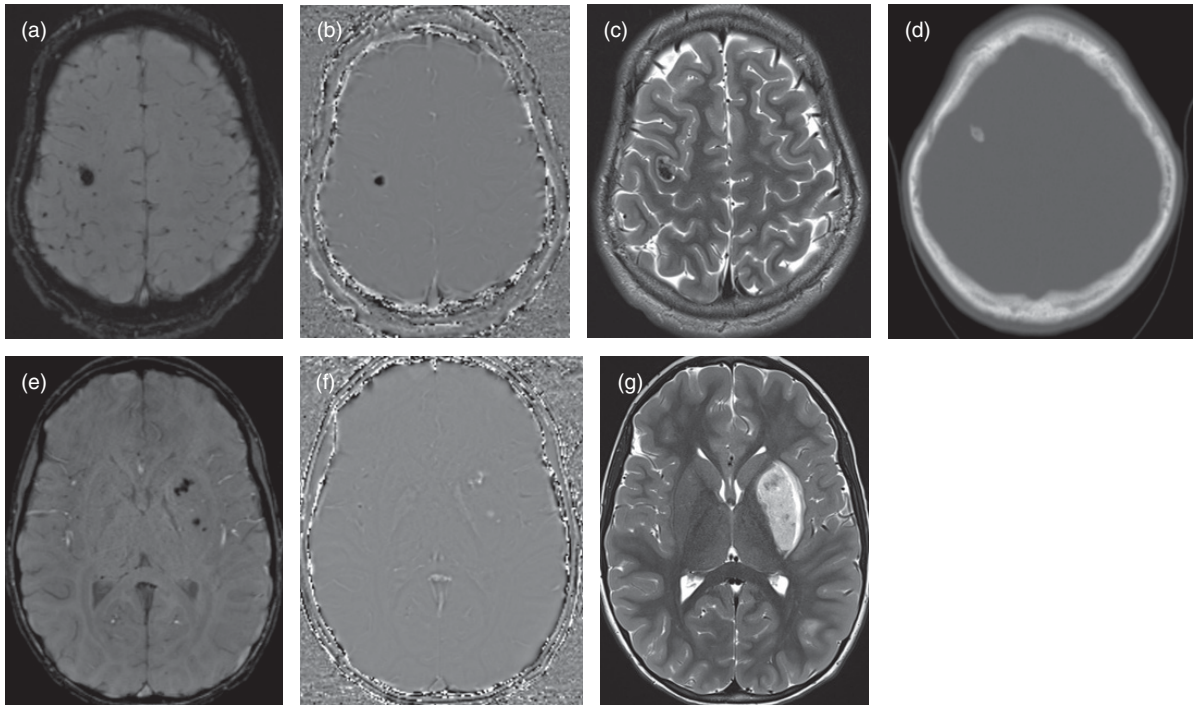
Characterization of mineralization by SWI. Susceptibility in a right frontal lesion (a) is characterized by the SWI phase map (b) as opposite phase to blood dephasing (i.e. black rather than white). The phase map enables inference of calcification as the basis of the susceptibility, suggesting that the small mass seen on T2-weighted imaging (c) is calcified as confirmed by non-contrast head CT (d). Conversely, the SWI phase map for a patient with a subacute basal ganglia infarct (e) demonstrates that susceptibility (f) in the infarct seen on T2-weighted imaging (g) represents petechial blood (white on phase map).
